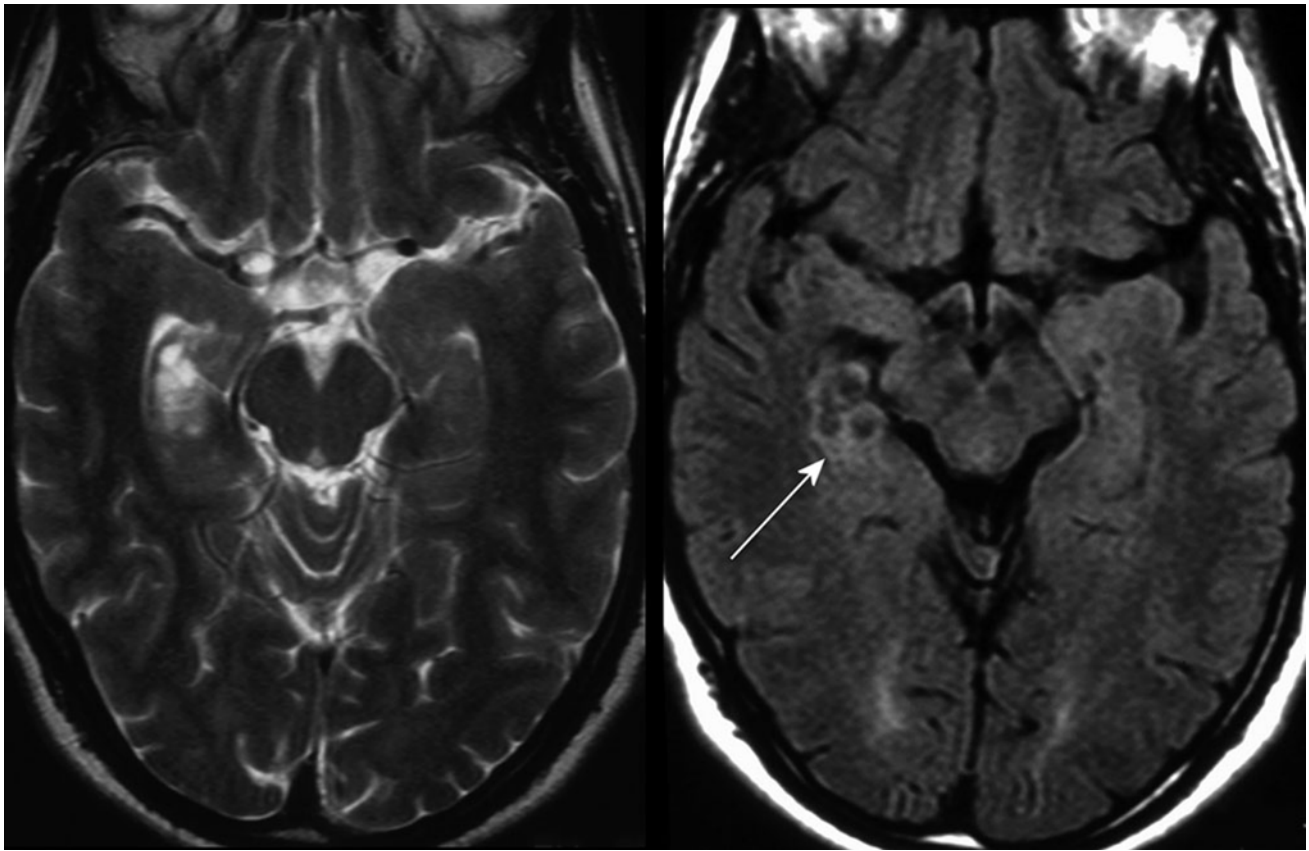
The temporomesial DNET shows typical well-defined hyperintense rings on FLAIR sequence
